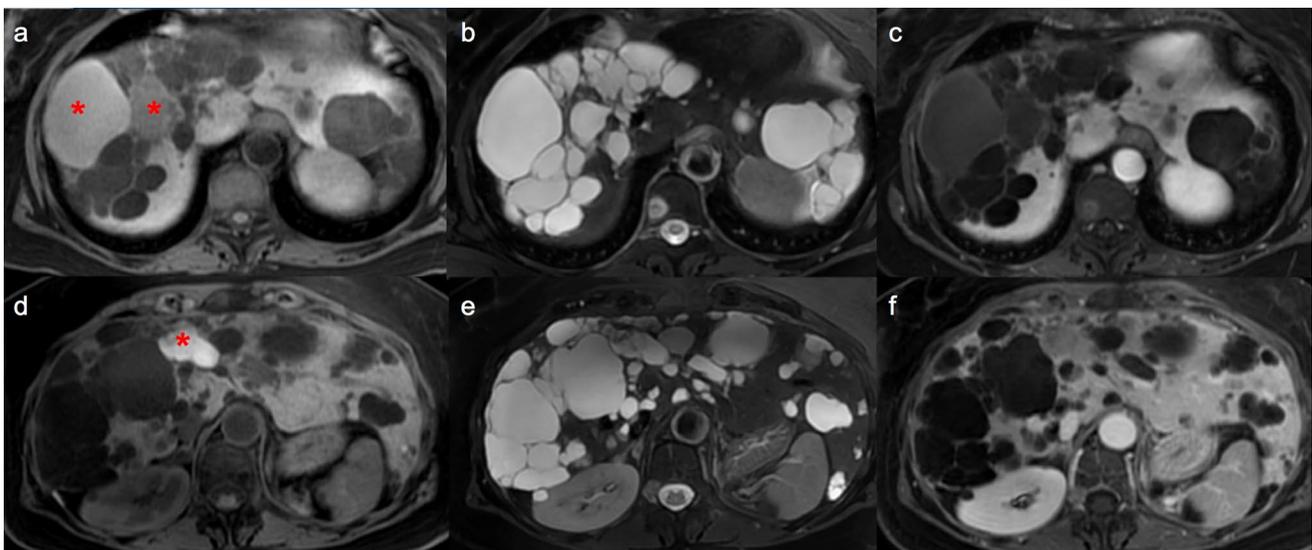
Polycystic liver disease. Axial T1-w (a), T2-w (b) and contrast-enhanced (c) MR images showing an enlarged liver with multiple diffuse thin-walled cysts varying in size, in patient with ADPLD.
